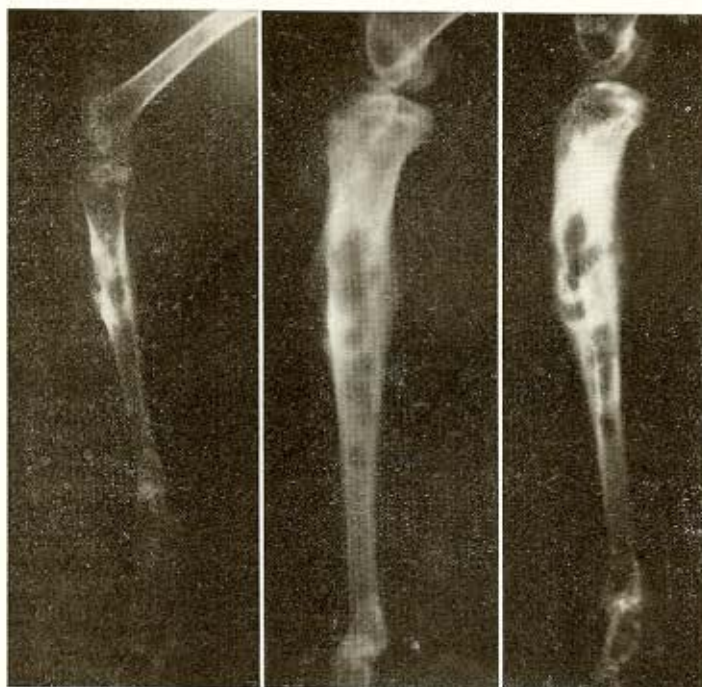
Reactivation of experimental osteomyelitis, corresponding to the case of fig. 1. Radiograph made 40 days after re-inoculation through the femoral artery with 3×10^8 staphylococci with 30 transfers; a — control 40 days after re-inoculation; b — control after 9 months of re-inoculation; c — 15 months after re-inoculation.
